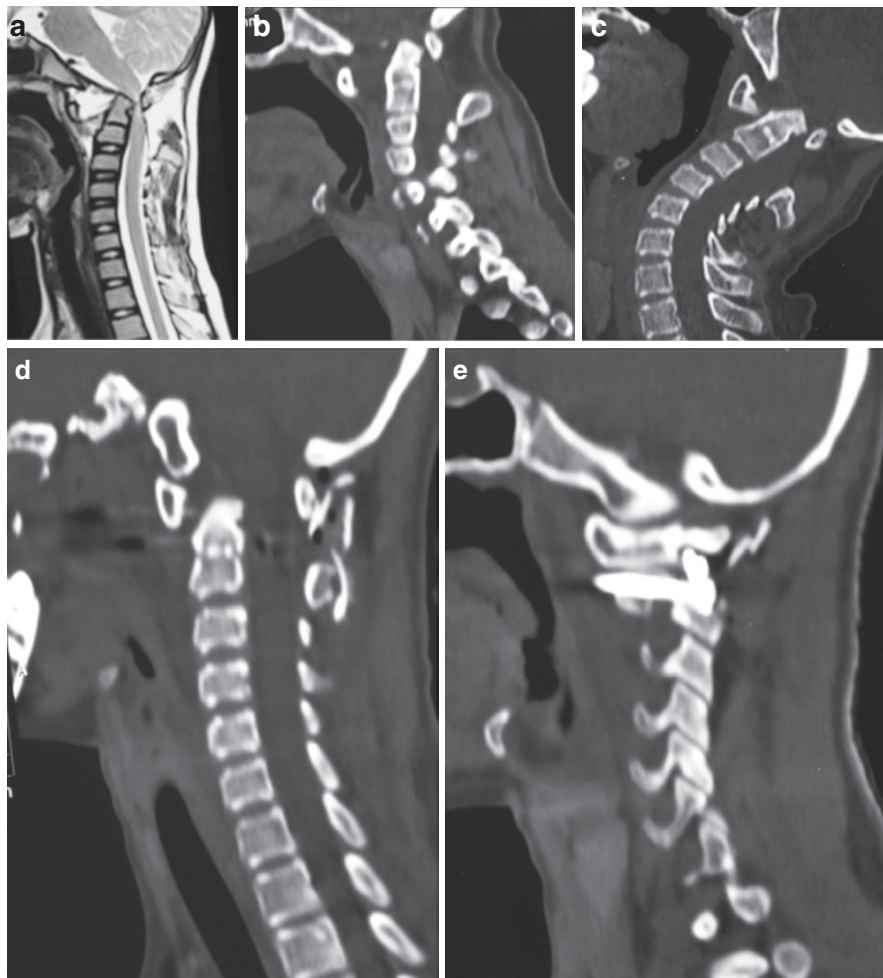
Images of an 18-year-old male patient showing “irreducible” atlantoaxial dislocation. (a) T2-weighted MRI showing atlantoaxial dislocation and cord compression by the odontoid process. (b) CT scan with the head in flexed position showing severe atlantoaxial dislocation. (c) CT scan with the head in extension position does not show any reduction in atlantoaxial dislocation. (d) Postoperative CT scan showing realignment of the craniovertebral junction and the atlantoaxial fusion. (e) Postoperative image through the facets showing lateral mass plate and screw fixation
